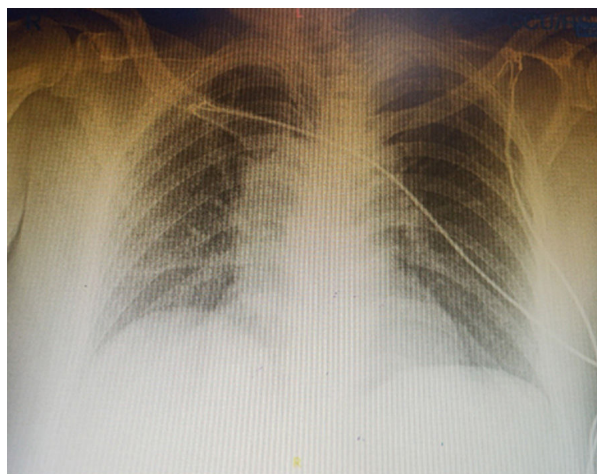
Chest Xray showing a Right Paratracheal Opacity
